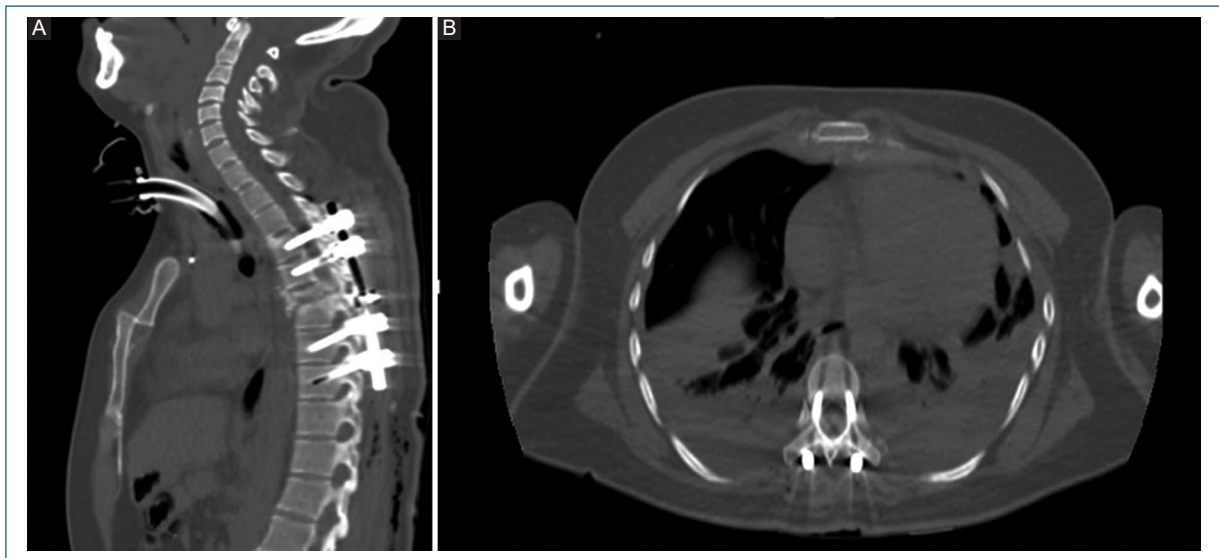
A: sagittal CT view of the spine post-surgery showing the results after laminectomy at T6-T7 with subsequent placement of transpedicular screws at T4-T5 and T8-T9, and open reduction of the fracture-dislocation. B: axial CT view of the spine at T5 level showing correct placement of the transpedicular screw.
